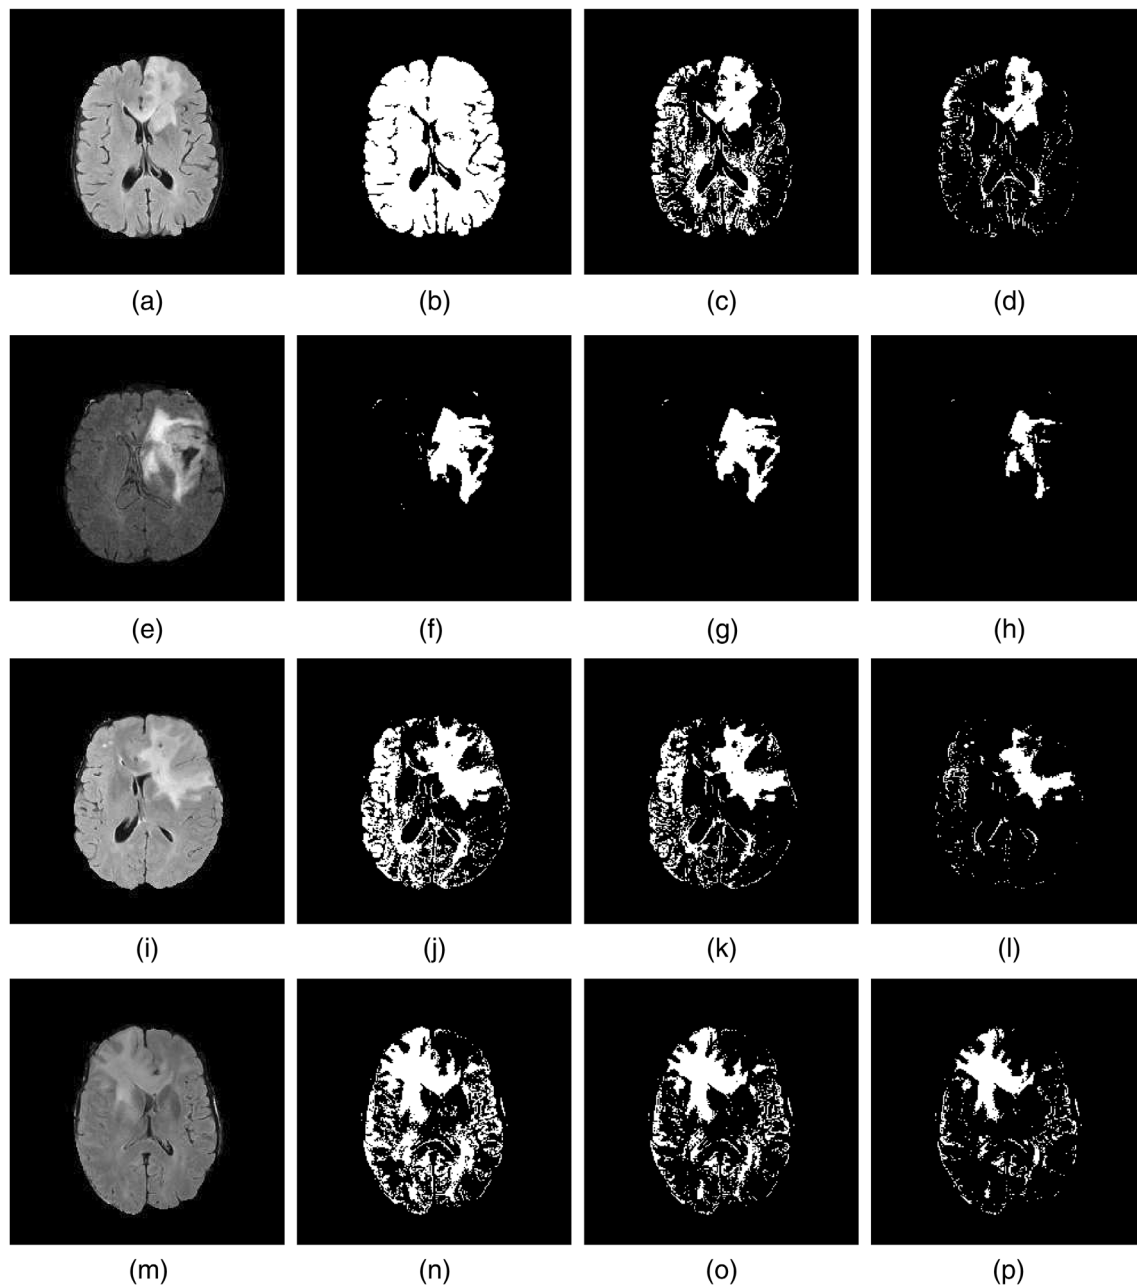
The first column, (a), (e), (i), and (m) are typical examples of FLAIR MRI images in a clinical setting. The second, third, and fourth columns are clusters extracted from corresponding images in the first column using k-means clustering algorithm with predefined numbers of clusters $k = 3$, $k = 4$, and $k = 5$, respectively
